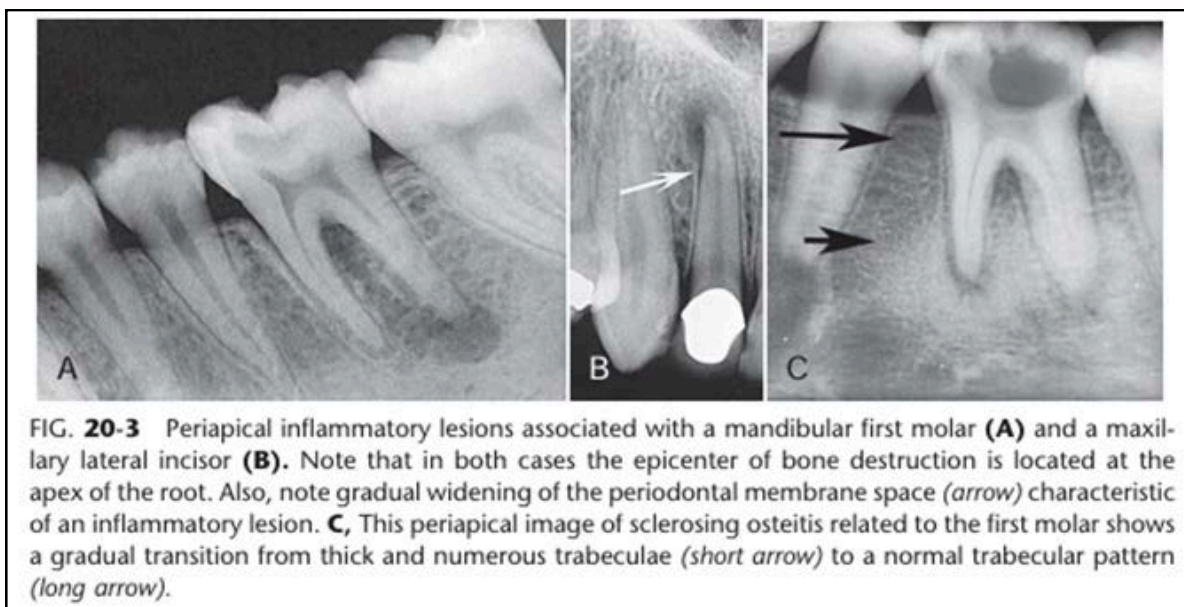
Periapical inflammatory lesions associated with a mandibular first molar (A) and a maxillary lateral incisor (B). Note that in both cases the epicenter of bone destruction is located at the apex of the root. Also, note gradual widening of the periodontal membrane space (*arrow*) characteristic of an inflammatory lesion. C, This periapical image of sclerosing osteitis related to the first molar shows a gradual transition from thick and numerous trabeculae (*short arrow*) to a normal trabecular pattern (*long arrow*).
